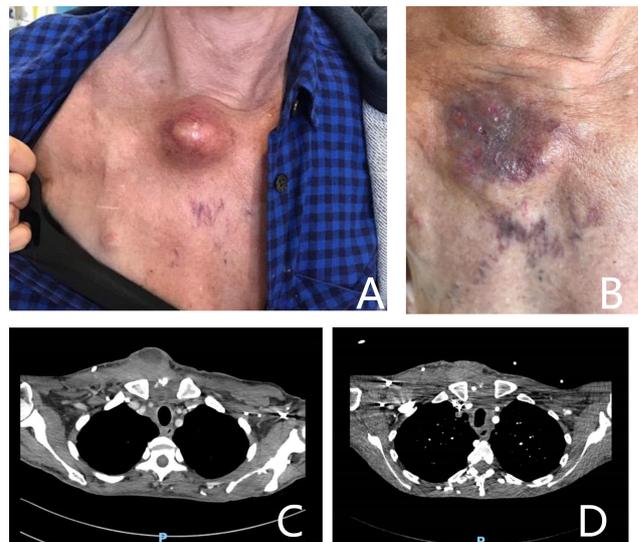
Patient B. (A) Pre-sternal lesion before CaEP. (B) Resolution of the lesion after CaEP. (C) CT image of pre-sternal lesion before CaEP. (D) CT image of the lesion after CaEP.
